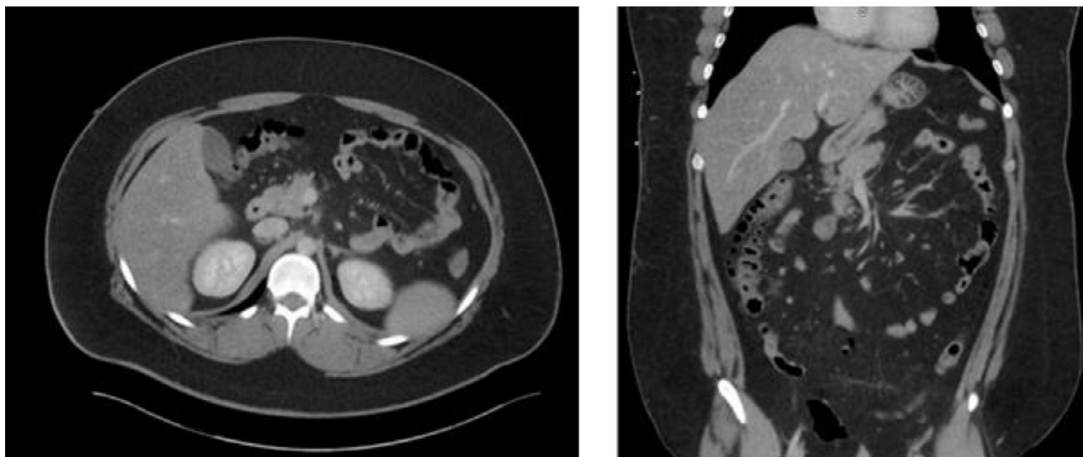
Axial and Coronal CT Obtained 22 months before presentation, with no evidence of liver masses.
